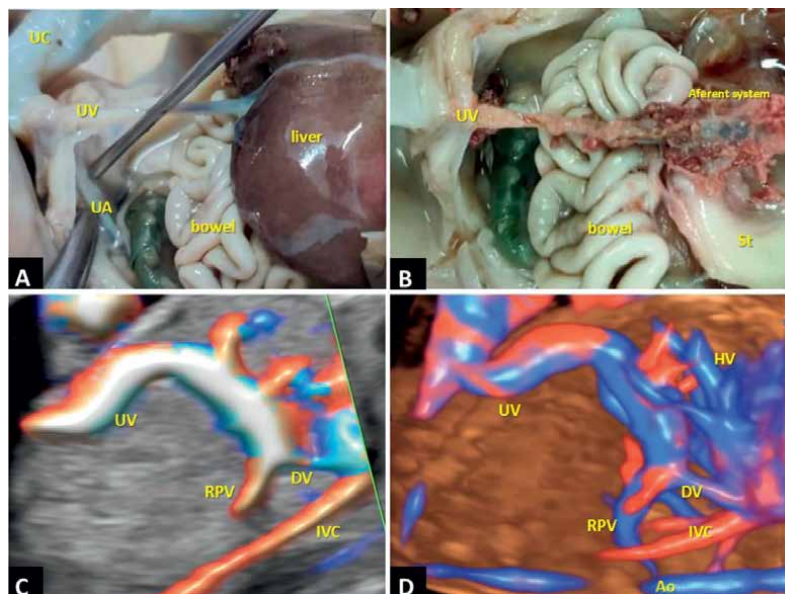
Macroscopic and ultrasound evaluation of the fetal liver. (A and B) Pathology examination shows the normal extrahepatic (A) and intrahepatic (B, liver tissue removed) pathway of the umbilical vein. (C) Longitudinal plane of the fetal abdomen, Color Doppler evaluation, showing the normal intrahepatic pathway of the umbilical vein and the normal aspect of the ductus venosus. (D) Longitudinal plane of the fetal abdomen, 3D rendering, which demonstrates the normal aspect of the afferent and the efferent hepatic systems. UV, umbilical vein; Ao, aorta; IVC, inferior vena cava; St, stomach; RPV, right portal vein; HV, hepatic vein; UC, umbilical cord; UA, umbilical artery.
